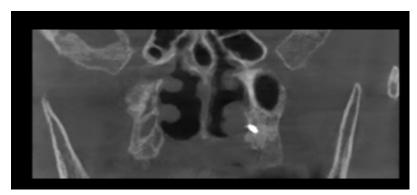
cone beam scan (CBCT) with sagittal view 2 years after treatment
